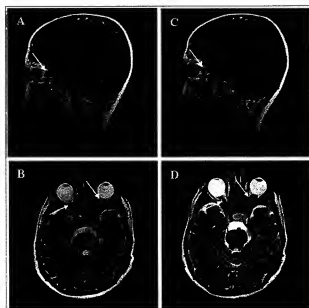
Sagittal T1-weighted magnetic resonance imaging scan (MRI) of the brain and orbits showing the glioma affecting the left optic nerve (white arrow) at baseline (A) and 4 months after nerve growth factor (NGF) administration (C). Axial T2-weighted MRI showing both right and left optic nerves involved by bilateral optic gliomas (white arrow) at baseline (B) and 4 months after NGF administration (D). No significant change in tumor volume after NGF treatment was found.
